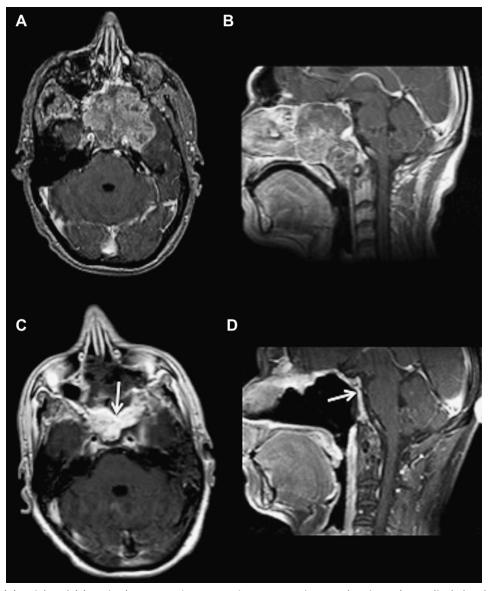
(A) Axial and (B) sagittal preoperative magnetic resonance images showing a large clival chordoma in a 41-year-old male patient, which demonstrates heterogeneous enhancement after intravenous contrast injection. This tumor involves the entire midline, extending anteroposteriorly from the posterior portion of the nasal cavities to the clival area and rostrocaudally down to the nasopharynx at the level of the C1-C2 junction, also invading the left cavernous sinus and reaching the ipsilateral MCF. (C) Axial and (D) sagittal postoperative magnetic resonance images after an endoscopic endonasal approach, demonstrating the complete removal of the lesion. The arrows indicate the enhancing nasoseptal flap that has been used to reconstruct the skull base defect.
